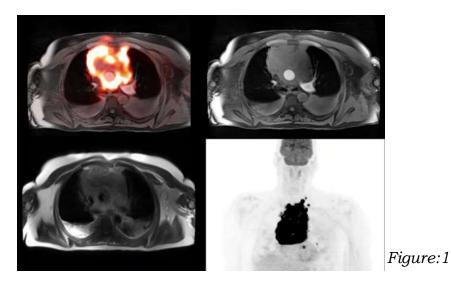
51 year old male with newly diagnosed diffuse large B-cell lymphoma and left vocal cord paralysis. PET-MRI demonstrates a large hyper metabolic mass in the anterior mediastinum encasing the great vessels (top left). The mass is iso intense on T1 radial VIBE (top right) and hyper intense on T2 weighted images (bottom left). PET MIP image shows the large mass with multiple small lymph nodes and lung nodules in the chest (bottom right).
